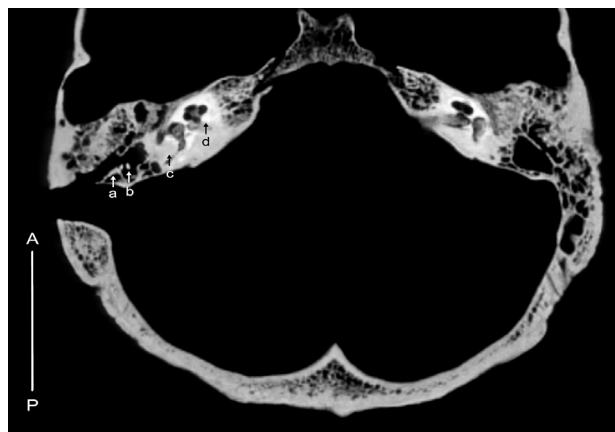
Axial CT scan of both tympanic – middle ear (ME) cavities and antra at the level of connection of the right mastoid trepanne canal with the posterior inferior antrum. Displaced antral position of incus (a) and malleus (b), posterior semicircular canal (c), otic capsule (d).
